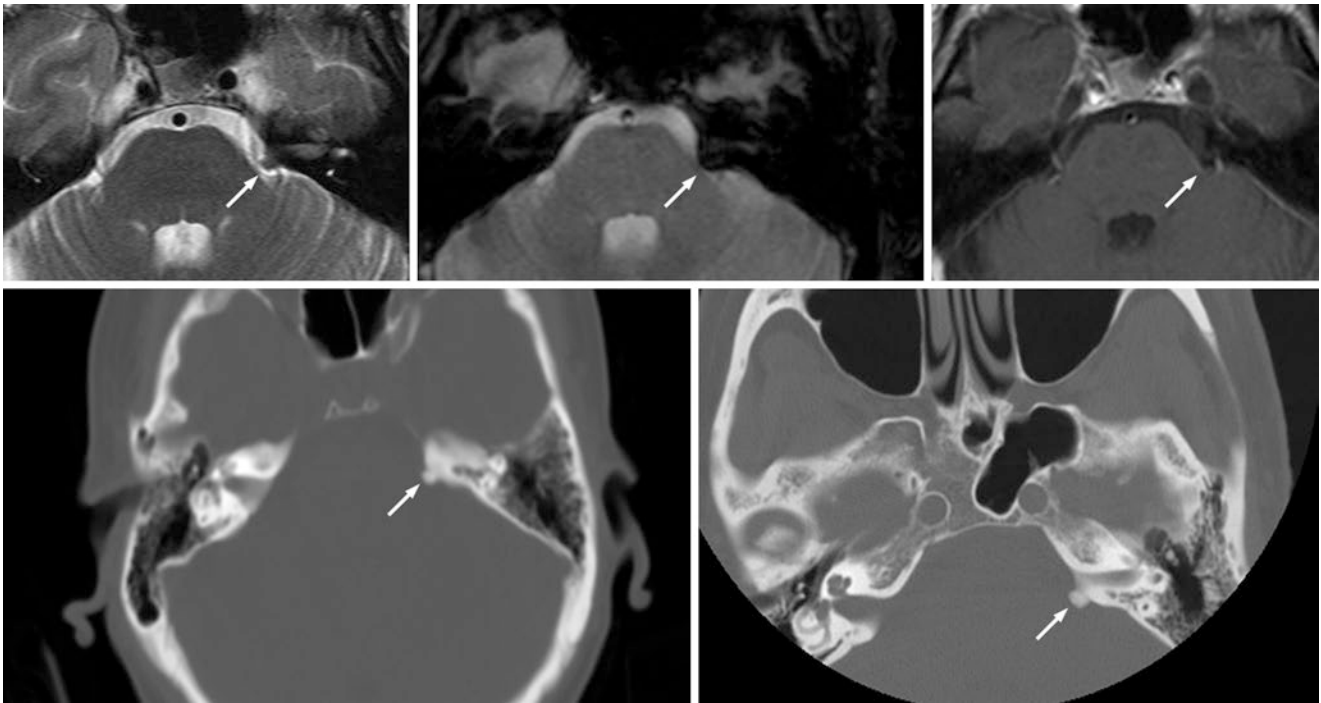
A 52-year-old patient. *Top row:* a focus of dark signal within the left cerebellopontine angle mimicked an extra-axial lesion such as an aneurysm or a calcified meningioma on axial T2WI (*left*), T2*WI (*middle*), and postcontrast T1WI MRI (*right*). *Bottom row:* an
